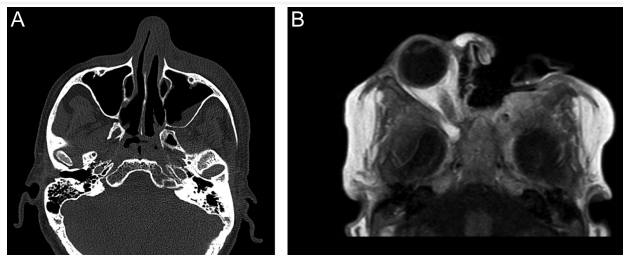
(A) Bone erosion in the posterior wall of the maxillary sinus on the left side and increased density in the periantral region on CT. (B) MRI of a patient with orbital exenteration.
